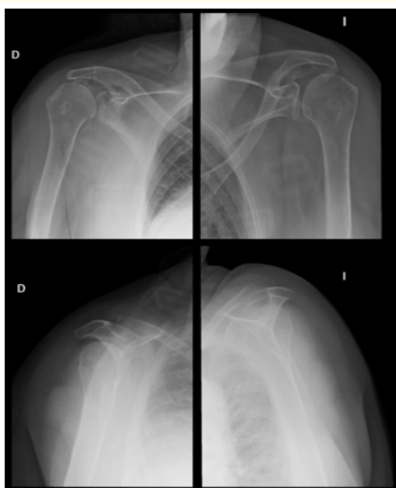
Post Reduction X-rays.
